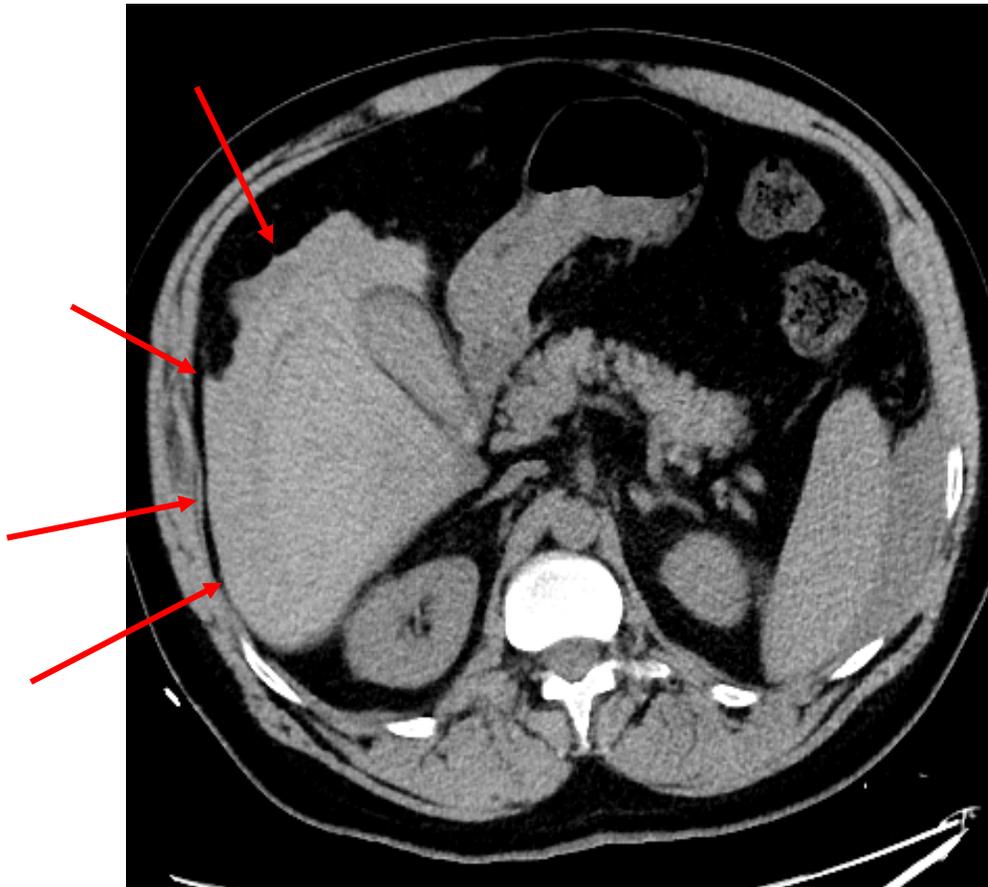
Non-contrast axial CT demonstrates a perihepatic hematoma adjacent to the inferior right hepatic lobe 9 hours after a CT guided random liver biopsy in a patient undergoing workup for cardiac transplant.
